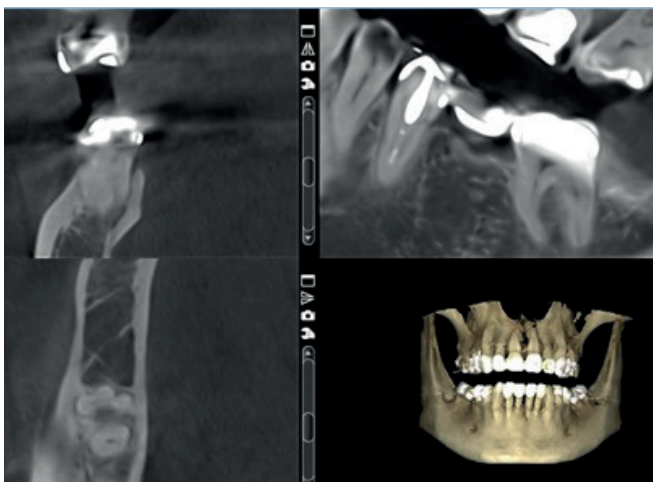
Cone-beam computed tomography: axial projection. The splitting of the mesial root of 37 teeth into three parts is visualized
